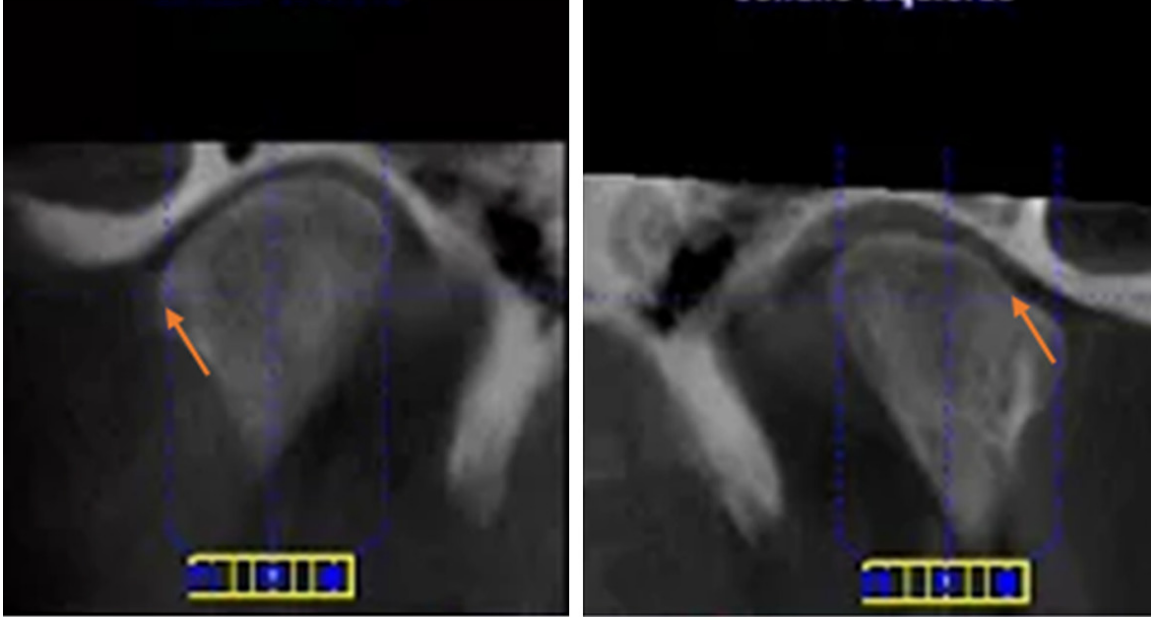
CT images of Male 77 years old. Left hand side: right condyle. Right hand side: left condyle. Left temporal bone and condyle erosion. Right condyle erosion.
